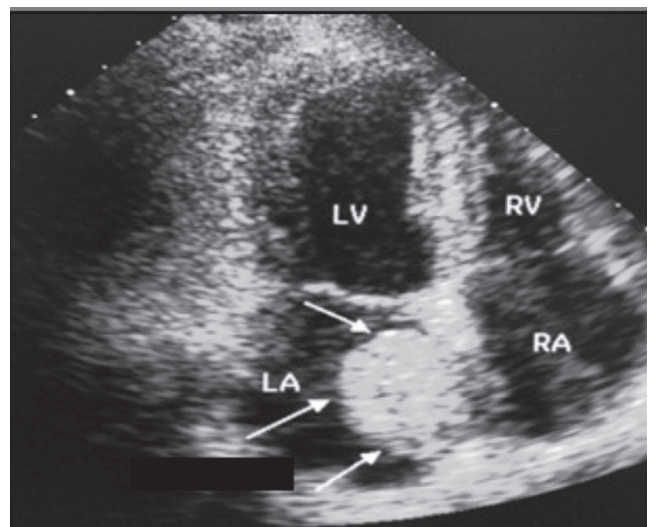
Preoperative transthoracic echocardiography demonstrates a round, mobile, pedunculated mass in the left atrium near the superior pulmonary veins originating from interatrial septum. LV indicates left ventricle; RV, right ventricle; LA, left atrium; RA, right atrium.
